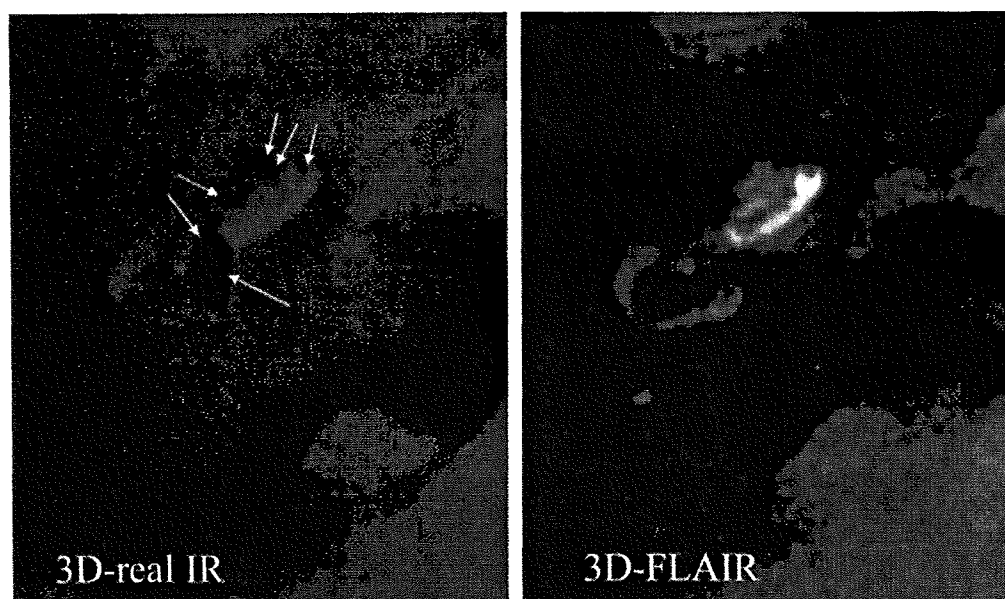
A 38-year-old man with right endolymphatic hydrops 1 day after intratympanic injection of Gd-DTPA. The 3D-real IR image reveals the enlargement of the endolymphatic space (black signal areas indicated by white arrows) in both the cochlea and vestibule. On the 3D-FLAIR image, the separation of the endolymphatic space and bone is unclear.
